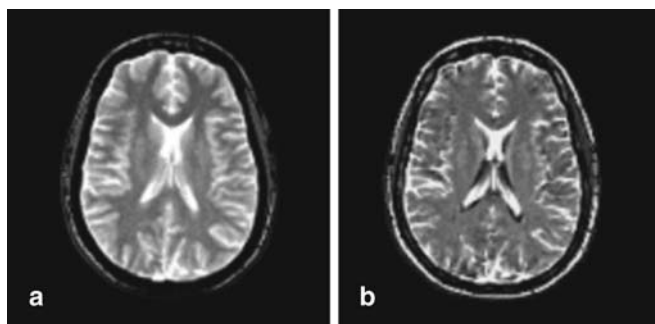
A 2D b-SSFP acquisition shows a transient contrast compared with b the T2/T1-weighted steady-state contrast of 3D b-SSFP
